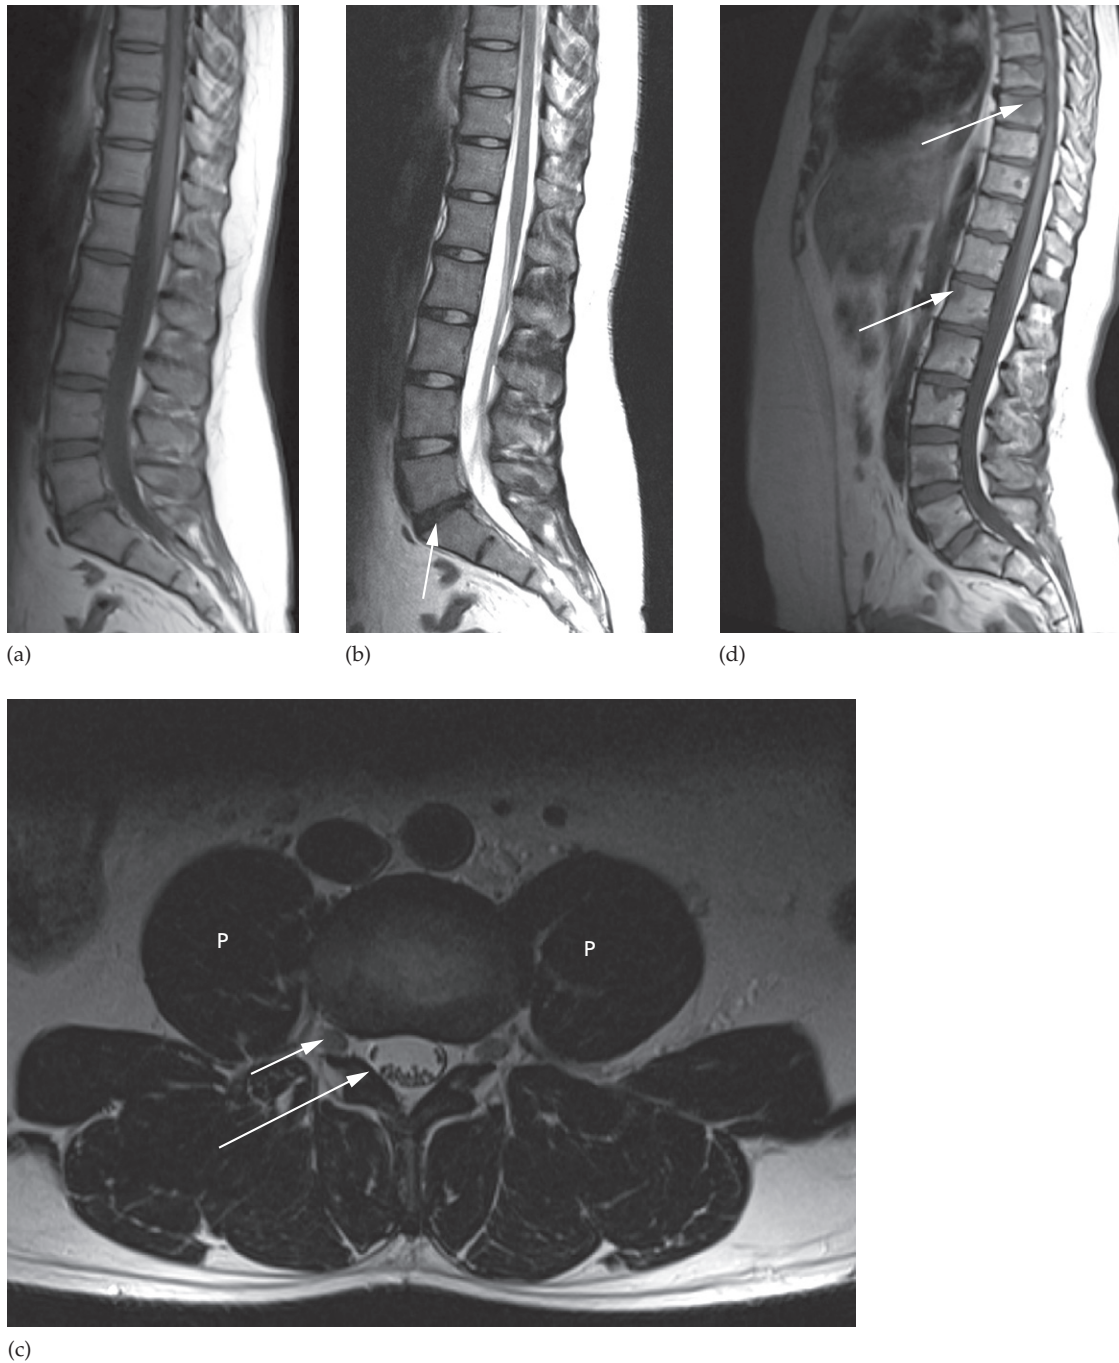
MRI of the lumbar spine. (a) Normal T1-weighted scan. The discs and spinal cord are of intermediate signal. (b) Normal T2-weighted scan. The discs and CSF appear as high signal. The L5/S1 disc has lost height and is reduced in signal compared to the other discs, in keeping with degenerative changes (arrow). (c) Axial T2-weighted scan through the L3/L4 disc space. At this level, the L3 nerve roots are in the exit foramina (short arrow) and the L4 nerve roots have moved to the edge of the dural sac (long arrow) in the lateral recesses prior to exiting the spinal canal at the level below. p, psoas muscle. (d) Sagittal T1-weighted scan showing focal areas of low signal within multiple vertebral bodies (some marked with arrows) due to metastatic breast cancer.
